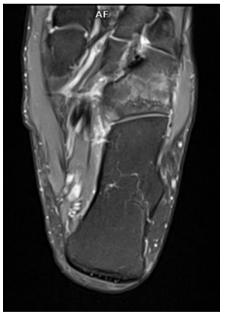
MR examination of the left ankle joint in Fig. 10. MR examination of the left ankle joint in the transverse plane; T2-weighted image fat-sat fracture of the cuboid bone.
